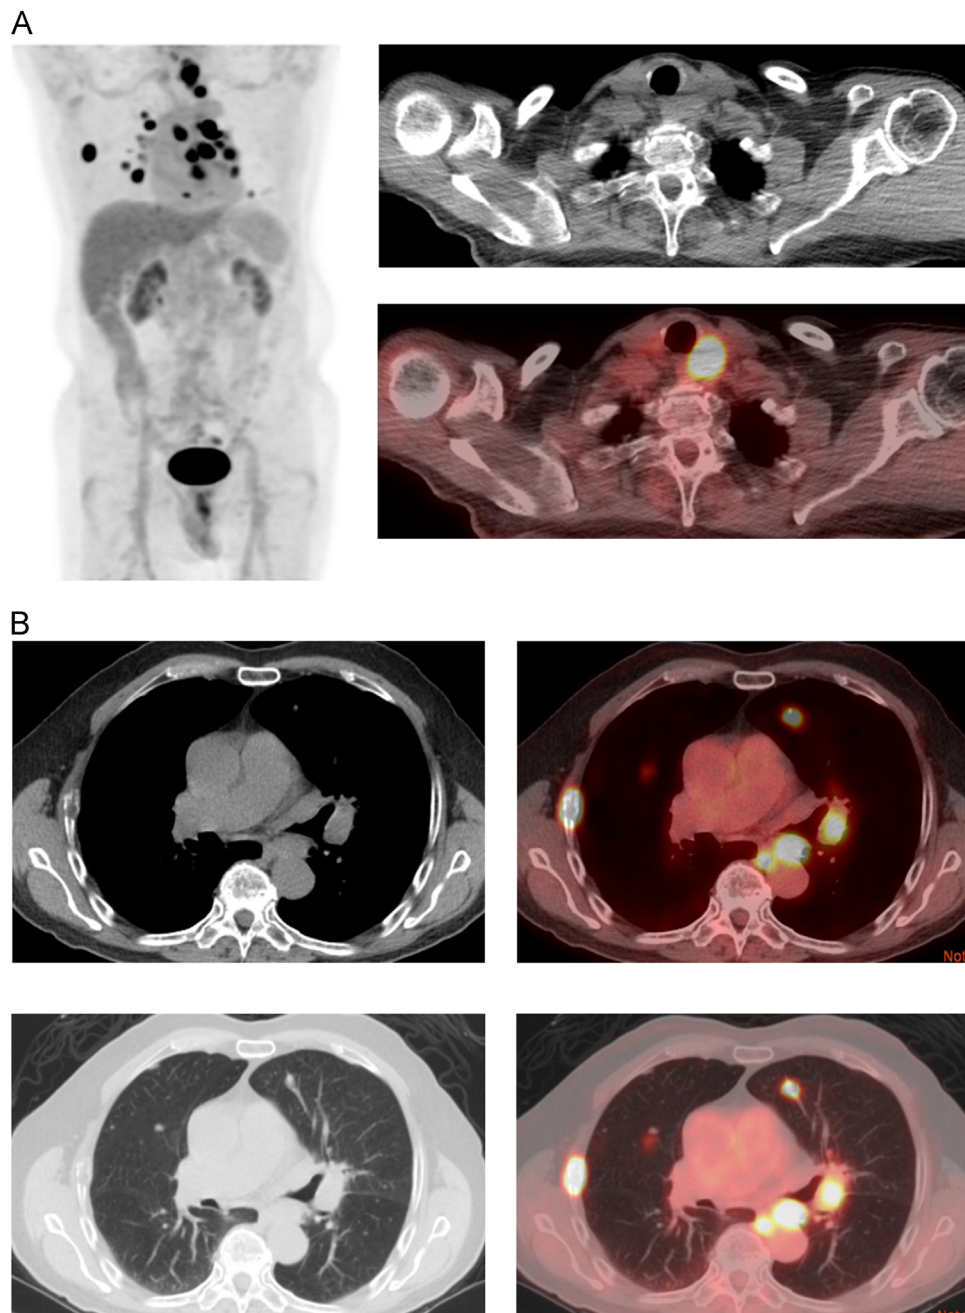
(A) FDG-PET MIP scan shows uptake in left tracheoesophageal groove mass, lung, thoracic nodal, and osseous metastases. (B) FDG-PET shows uptake in lung, thoracic nodal, and osseous metastases. MIP, maximum intensity projection.
